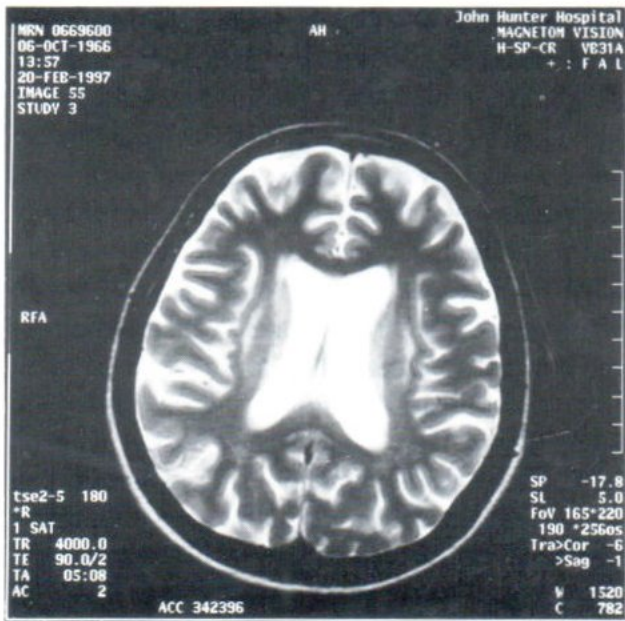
T2 -weighted MR image shows a thick hyperintense claustrum. Both caudate nuclei are hyperintense..
